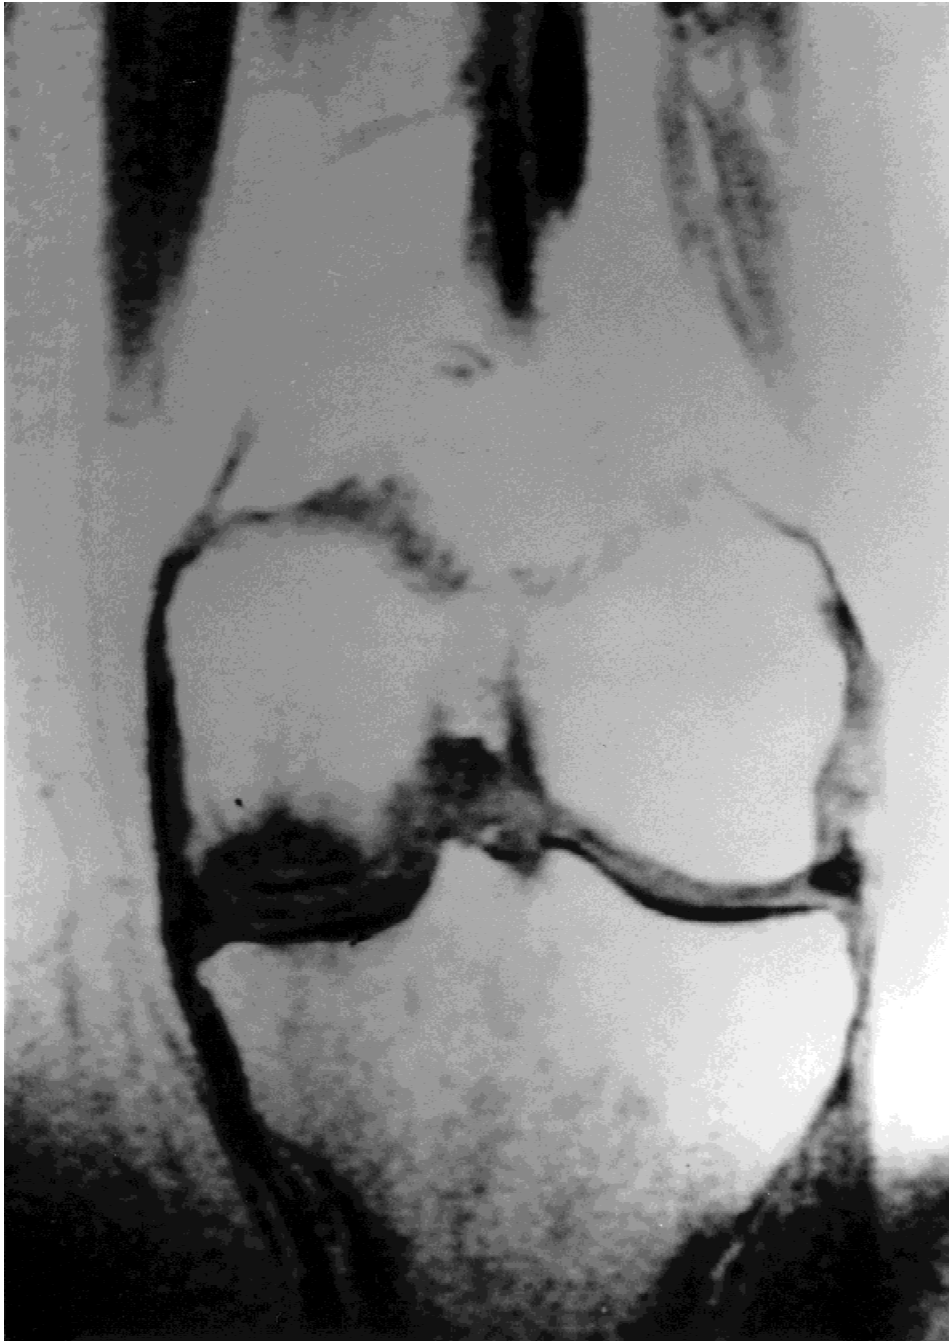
MRI, coronal section, showing osteonecrosis of the medial femoral condyle.
